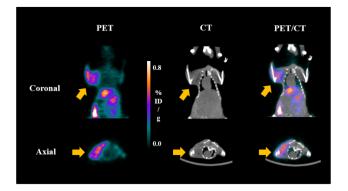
MicroPET, CT and PET/CT fusion images of a muscle infected model with *Aspergillus funigatus* (yellow arrow) at 2 h after *i.w.* injection of [¹⁵F]FDS.
